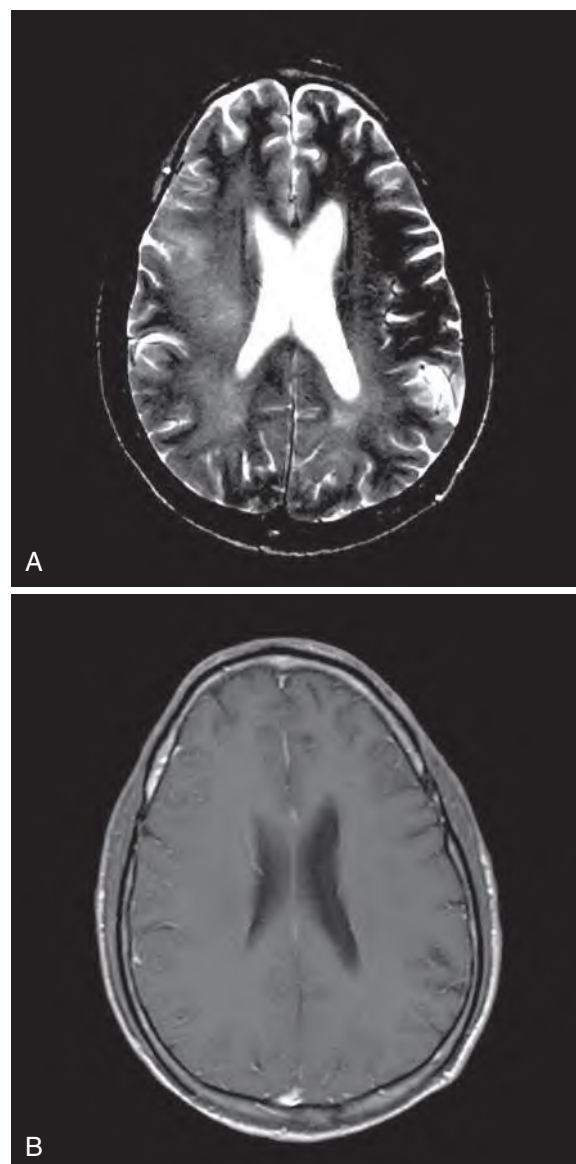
Brain magnetic resonance images of a 42-year-old man with human immunodeficiency virus-associated neurocognitive disorder. The T2-weighted image (A) shows bilateral, ill-defined hyperintense signal in the periventricular white matter and centrum semiovale, which does not enhance with gadolinium injection on the T1-weighted image (B). The ventricles are slightly enlarged, consistent with subcortical atrophy.
